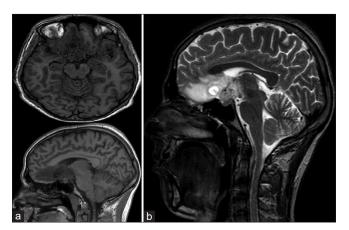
Brain magnetic resonance imaging shows a sellarsuprasellar lesion, (a) isointense to hypointense on T1 and (b) isointense to hyperintense on T2.
